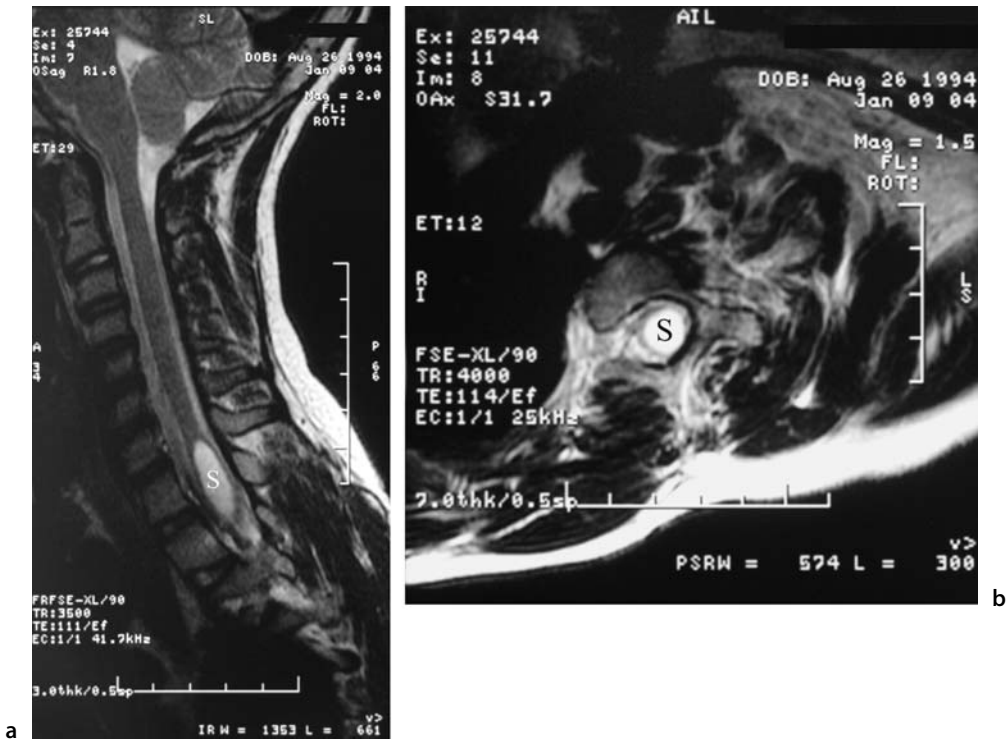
A 10-year-old with weakness. Sagittal (a) and axial (b) T2-weighted images of the cervical spine show a large high signal lesion (S) within the spinal cord. It is a fluid collection called a syrinx. It thins the neural tissues
